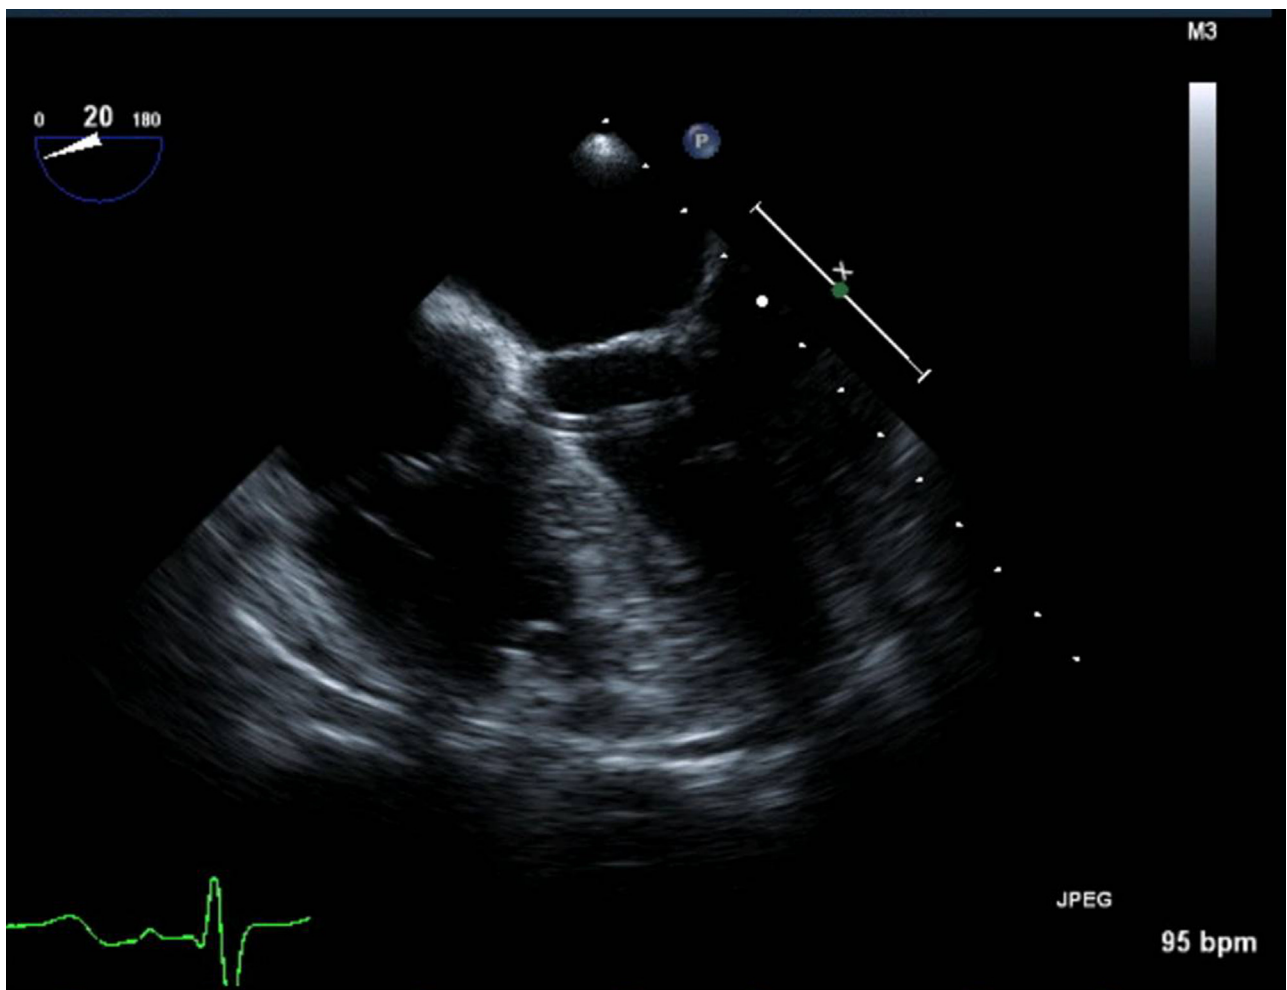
An ultrasonogram of left ventricular penetration complicating a transeptal puncture during an electrophysiologic study.
